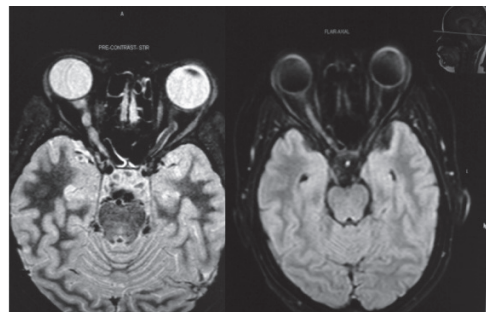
MRI Brain shows hyper intensities of bilateral optic nerve on pre contrast STIR, pre contrast FLAIR AXIAL views respectively
